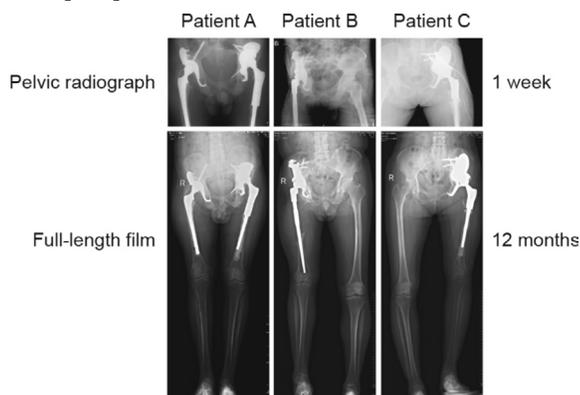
X-rays showing prosthesis evaluation after 1 week and 12 months that demonstrating stable fixation without any
